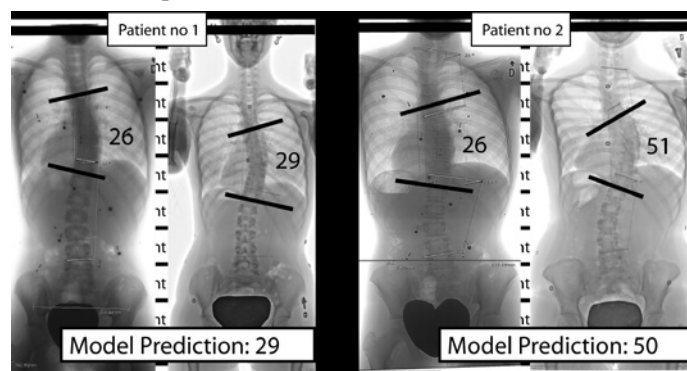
Example of 2 patients. Left radiograph is from first visit and right radiograph at skeletal maturity.
